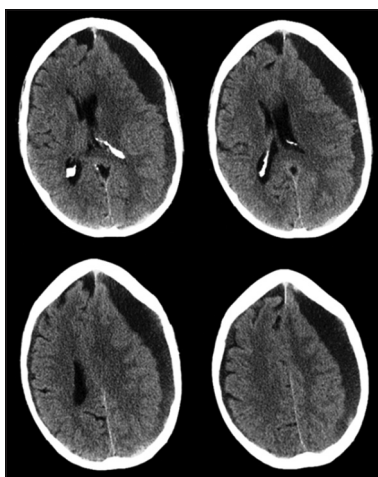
CT head from referring hospital. Left sided subdural collection causing midline shift, effacement of the ipsilateral ventricle, sulci and guri. Small collection is evident on the right side as well
